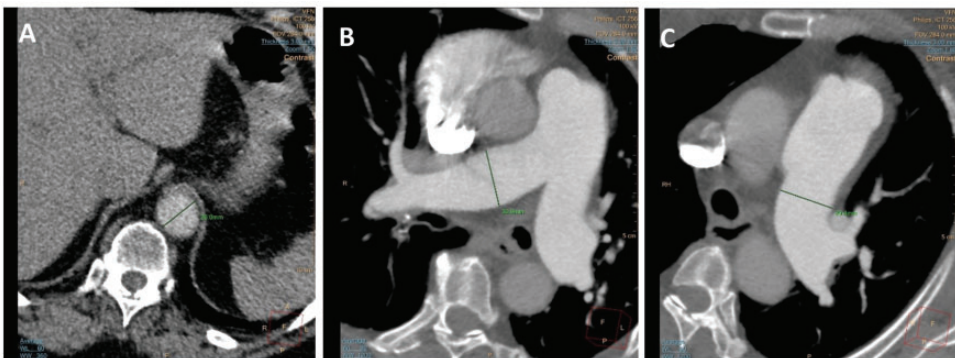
Computed tomography images showing measurement of the a) descending aorta diameter, b) right pulmonary artery diameter, and c) left pulmonary artery diameter.
